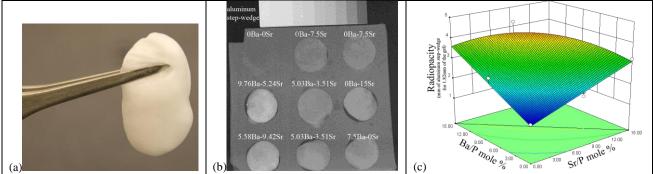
(a) Image of a gel, (b) X-ray image of gels compared to an aluminum step-wedge and (c) Radiopacity model produced by Design-Expert[®] for medium chain length polyphosphate at fixed [polyphosphate] of 3 g/mL.
